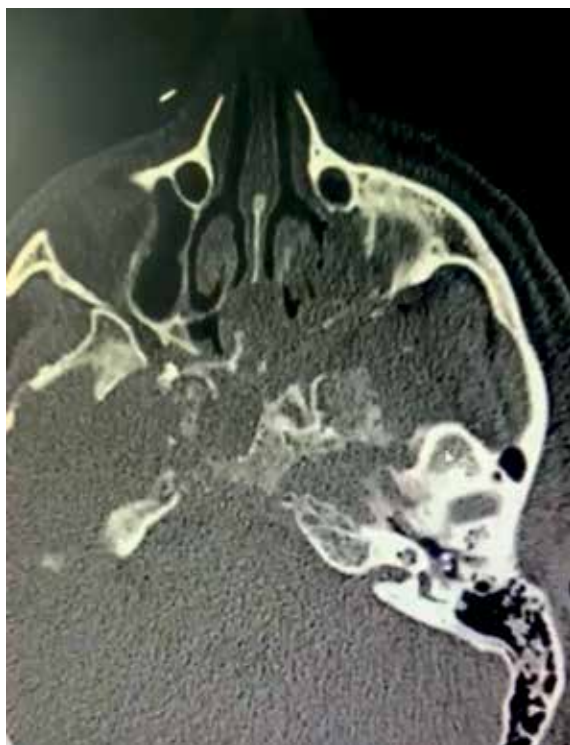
Chronic sinusitis and osteolysis at the ethmoid level, skull base, a Post-Covid patient, see native skull CT examination, “Alexandru Gafencu” Military Emergency Hospital Constanta, 2021, own source
